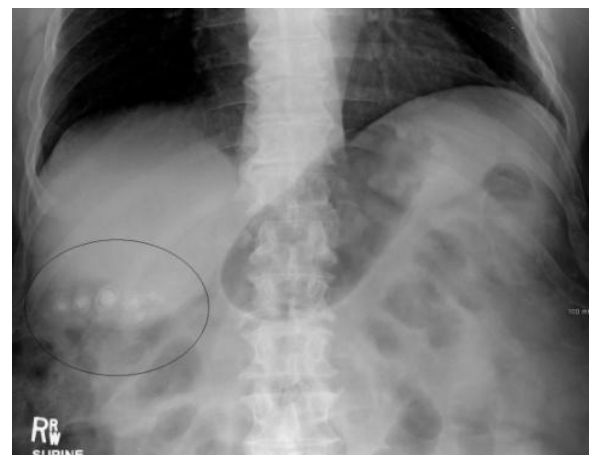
2 Gallstones as seen on plain X-ray
